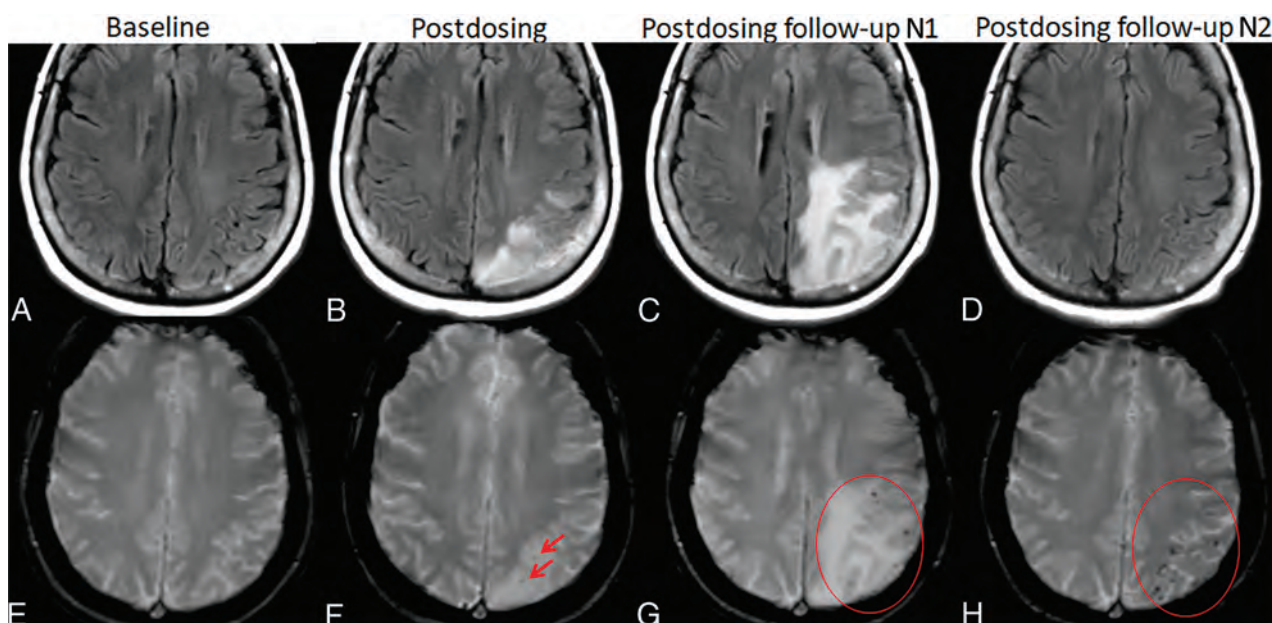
ARIA-E and -H. Patient on anti-amyloid therapy who developed ARIA-E (T2-FLAIR, A–D) and ARIA-H microhemorrhages (T2*-GRE, E–H). On postdosing T2-FLAIR (B), new left parietal T2-FLAIR hyperintense signal involving the cortex and subcortical white matter with associated local mass effect, consisting of sulcal effacement and gyral expansion. Despite suspension of dosing, the extent of T2-FLAIR abnormality and mass effect progressed at the postdosing follow-up No. 1 (1 month). ARIA-E resolved by postdosing follow-up No. 2 (2 months). On postdosing T2*-GRE, 2 new, treatment-emergent microhemorrhages (mild ARIA-H, F, red arrows) that increased in number over postdosing follow-up examinations with severe ARIA-H at postdosing follow-up No. 2 (H, red circle).
